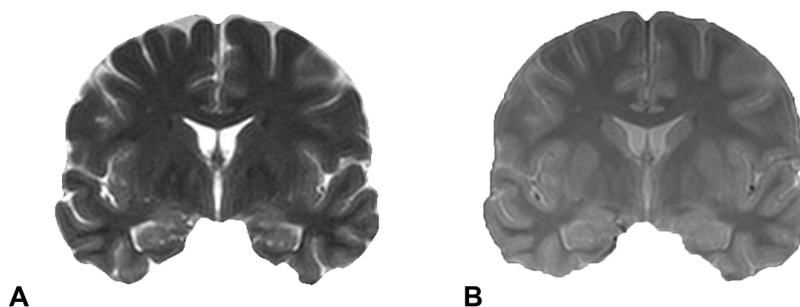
Removal of the background from the T2-weighted image (A) and PD-weighted image (B).
